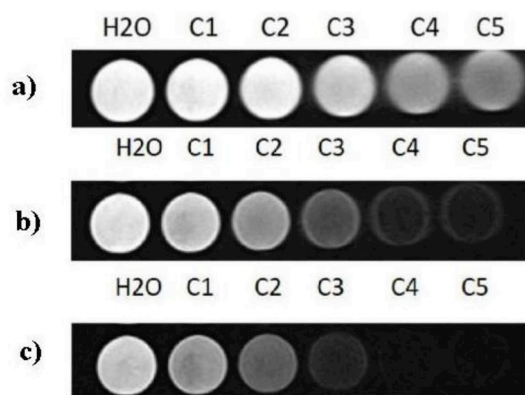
T_2 -weighted MRI of L3@PMAO at different conditions, (a) TE = 11 ms, TR = 3970 ms; (b) TE = 34 ms, TR = 3970; (c) TE = 91 ms, TR = 3970 ms. (H₂O, C1, C2, C3, C4 and C5 are at concentration of 0, 10, 15, 20, 30 and 45 μg iron/ml, respectively).
